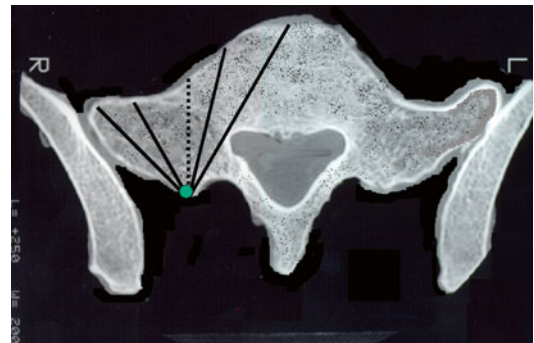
CT showing the angles of screw insertion
